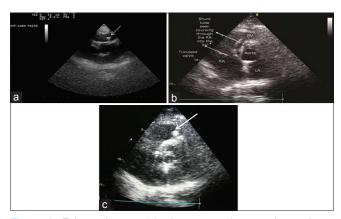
Echocardiogram (a) white arrow showing shunt tube in right atrium (b) shunt tube coursing from right atrium to right ventricle (c) white arrow showing vegetation adjacent to calcified shunt tube
